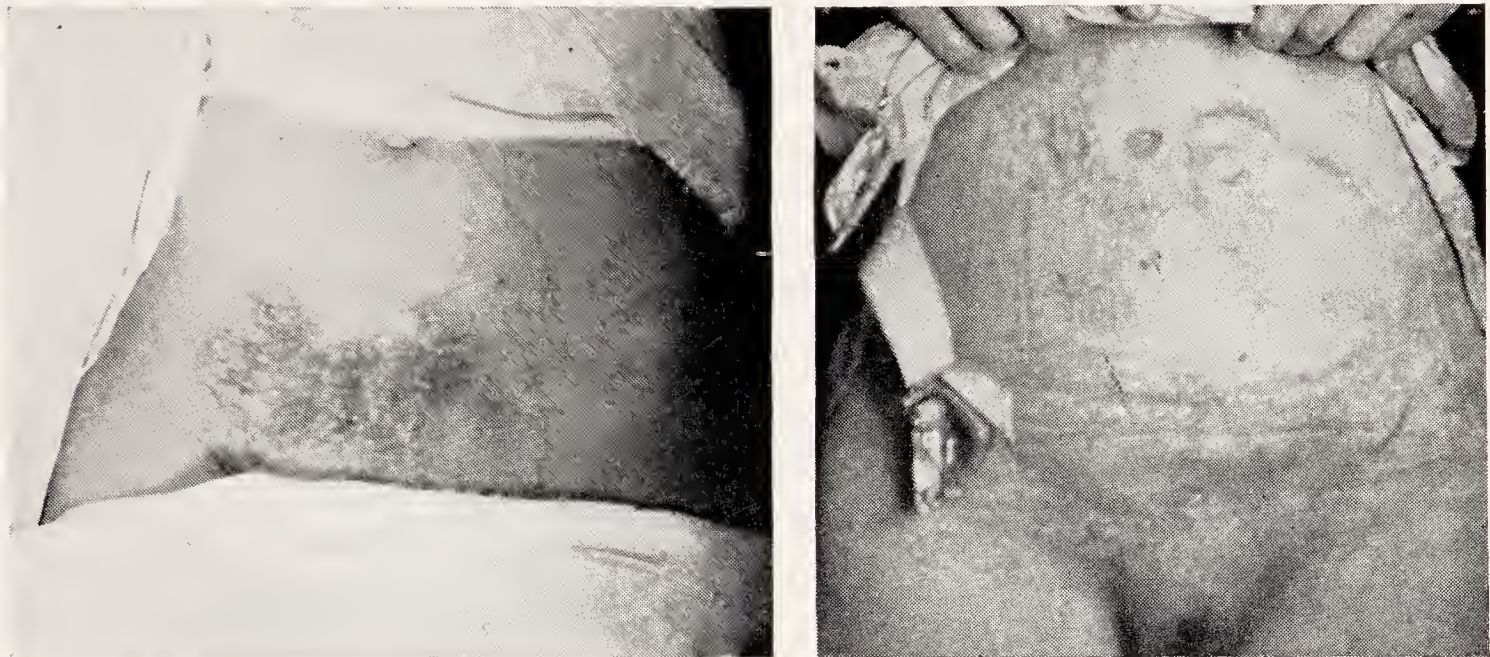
Before and after operation for the removal of an x-ray burn of the abdominal wall. In this case a double pedicled flap was moved downward after excision of the burnt area and a skin graft was placed on the denuded area which remained above.
